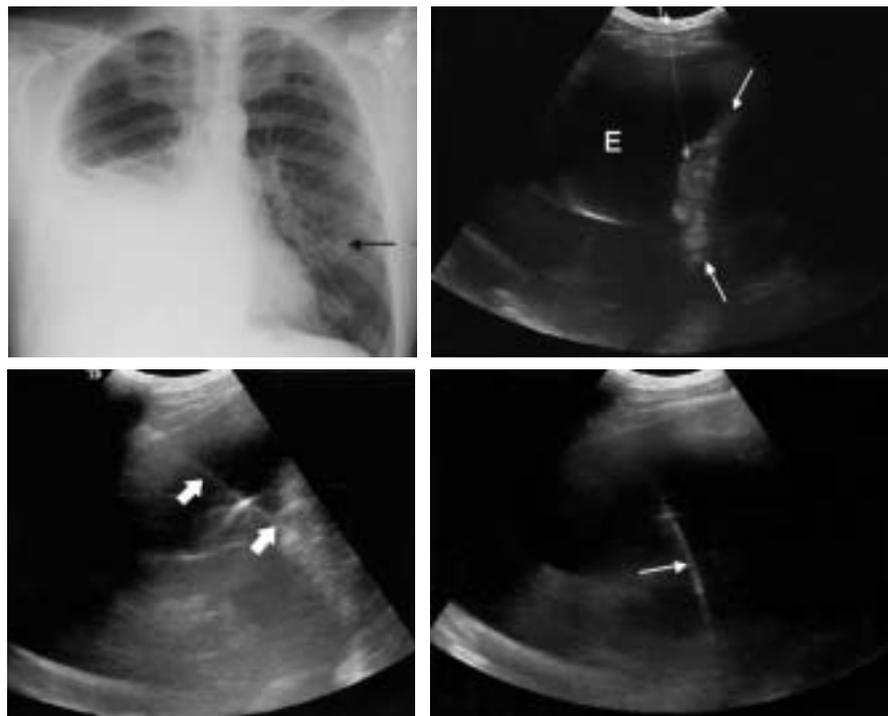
Top left, Frontal chest radiograph showing a moderate-sized right pleural effusion with opacification of the middle and right lower lobes and a left lung metastatic nodule (arrow). Top right, Sagittal ultrasonogram of the lower right side of the chest showing an anechoic effusion (E) with a lobulated echogenic mass along the diaphragmatic pleura (arrows). Bottom left, Image obtained during ultrasonographic biopsy showing biopsy needle (arrows) traversing effusion and entering diaphragmatic mass. Cytologic evaluation confirmed metastatic adenocarcinoma consistent with a renal primary tumor. Bottom right, Image obtained during placement of a guidewire (arrow) for insertion of a 14F catheter for drainage and subsequent talc sclerosis.
